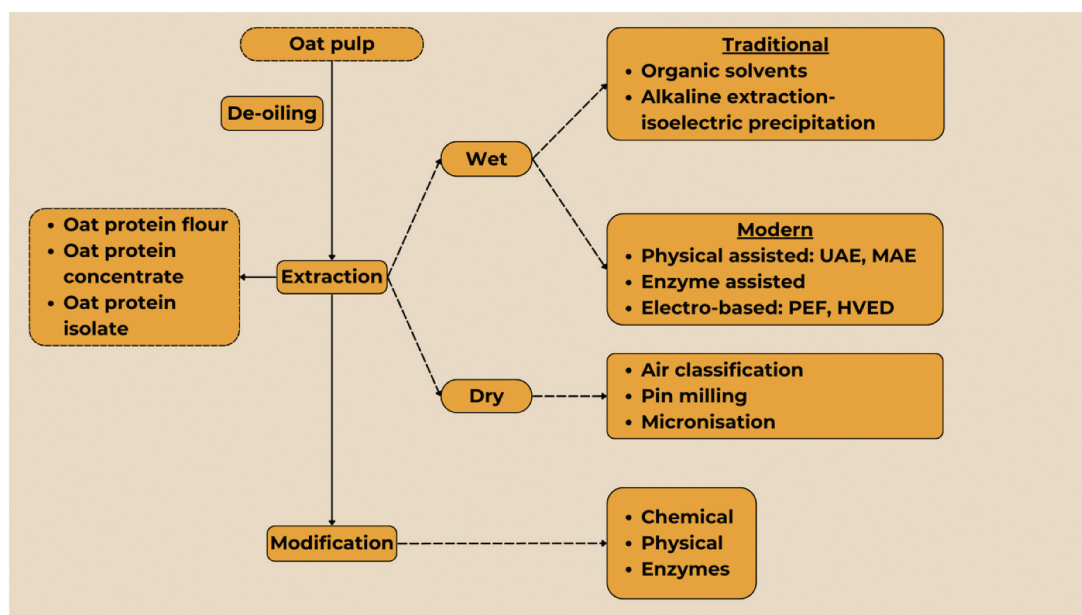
Extraction and modification of oat protein. UAE: ultrasound-assisted extraction; MAE: microwave-assisted extraction; PEF: pulsed electric field; HVED: high voltage electric discharge.
